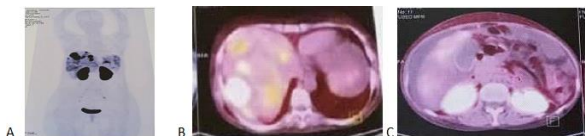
OctreoScan showed intense radiotracer uptake in the pancreatic region and multifocal hepatic lesions (A), and Ga-68-DOTATATE –PET/CT SCAN showed an avid tumoral mass in the pancreatic tail compatible with the known primary tumor, metastatic lesions in both hepatic lobes (B, C).
